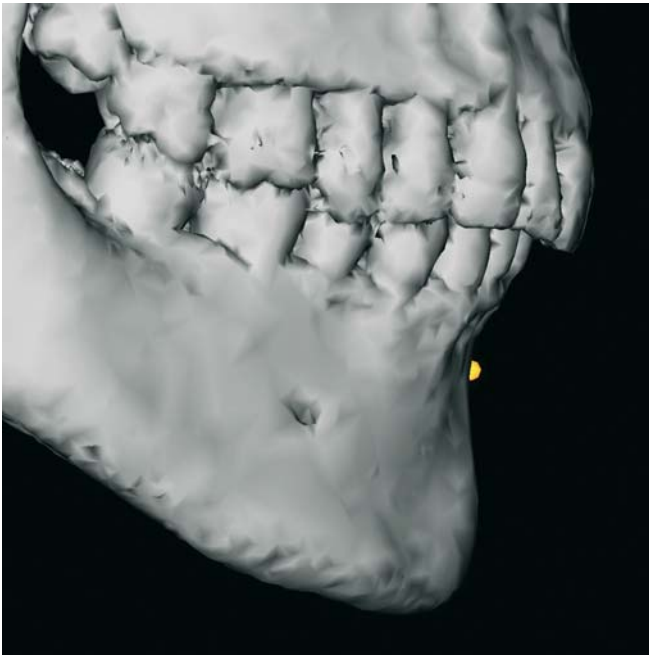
B-Point. Profile view right (3-D CT, patient K.C.)
